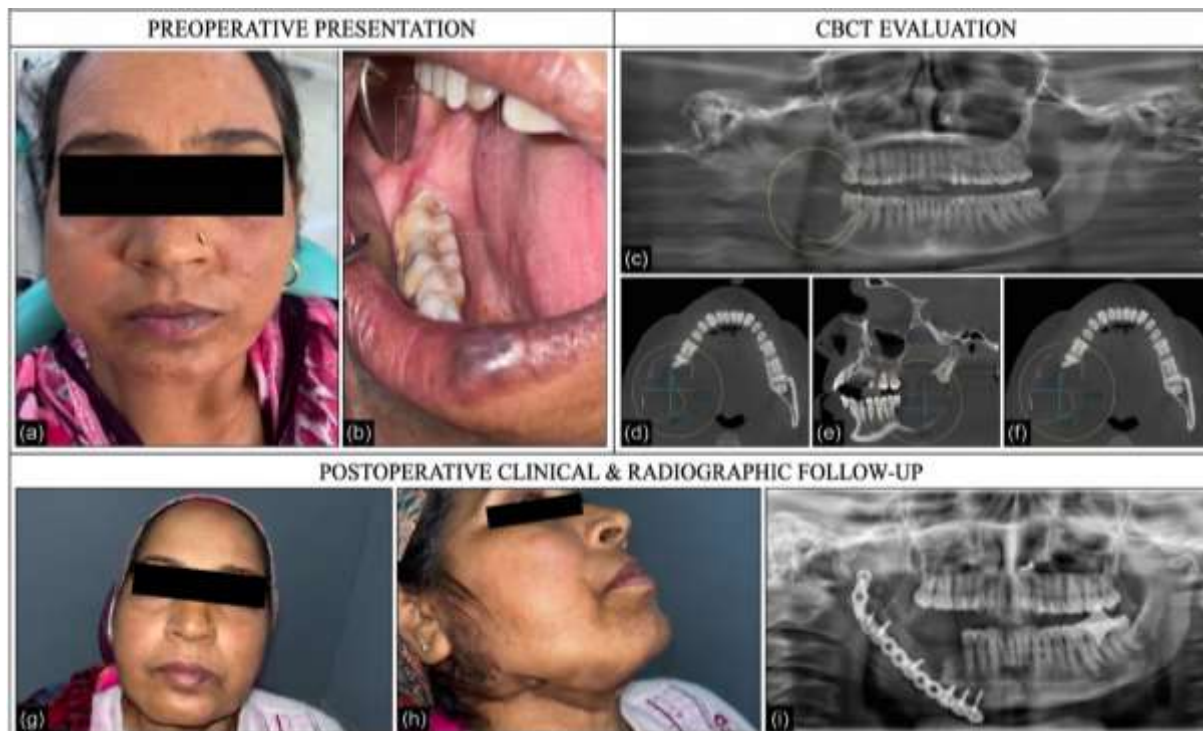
Comprehensive Pre-operative and Post-operative Clinical and Radiographic Presentation.
